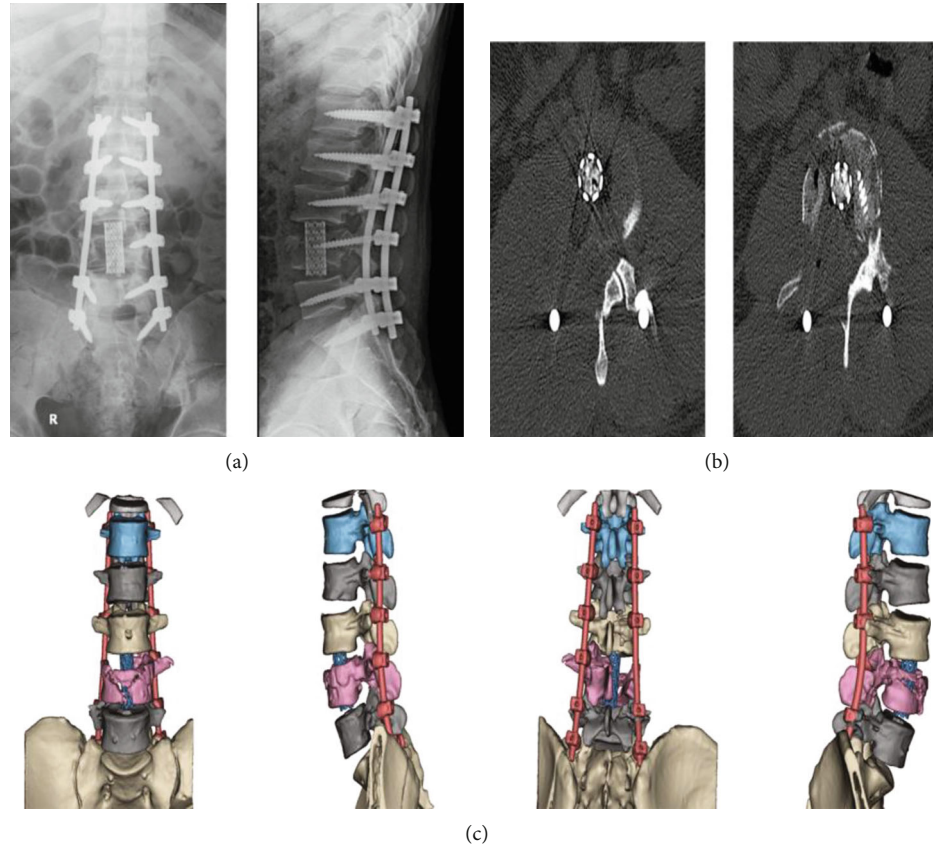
The X-rays and CT results of the abovementioned case identified in Figure 1. (a) X-rays of lumbar postsurgery. (b) CT of lumbar postsurgery. (c) Three dimensional CT images of lumbar postsurgery.
